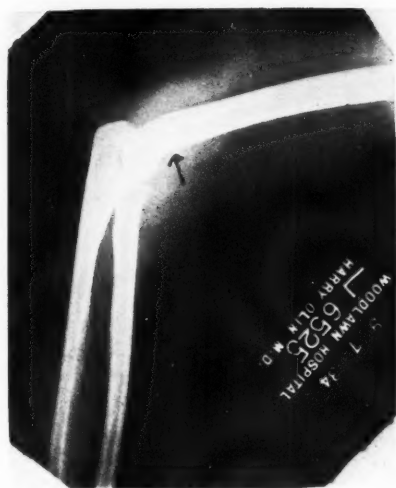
Case 1. Roentgenogram taken on Sept. 7, 1934. Note destruction of periosteum at the point indicated by the arrow.
